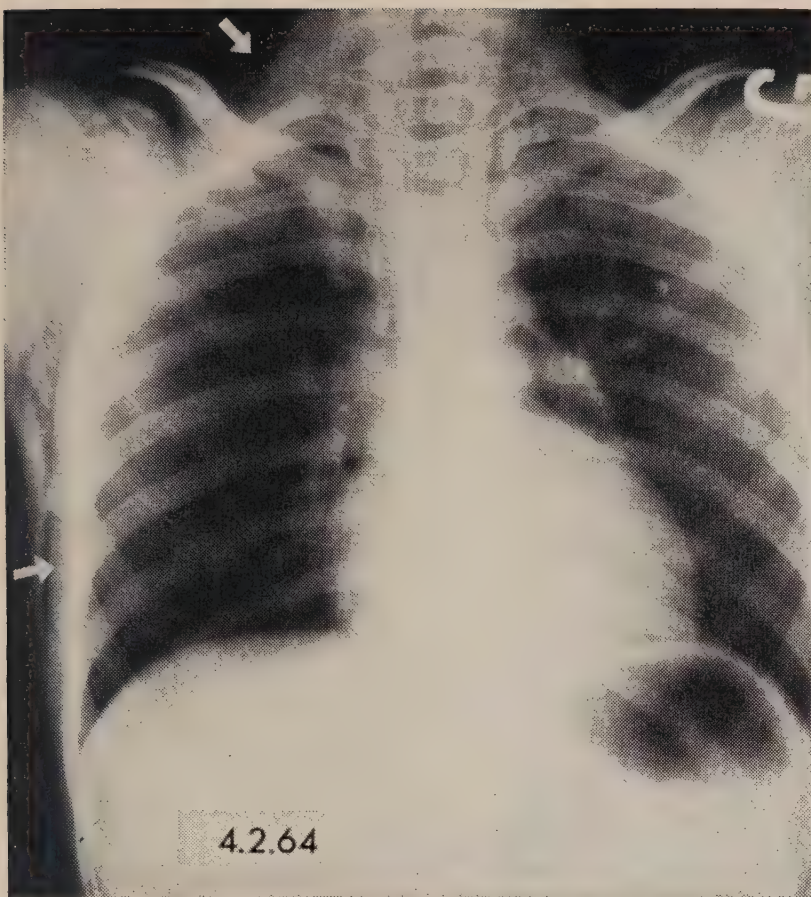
Radiographies de face et de profil prises immédiatement après l'accident rapporté. Les flèches montrent l'air dans les tissus sous-cutanés, au niveau de la cage thoracique. L'air repousse les tissus mous du grill costal. (4-2-64)
